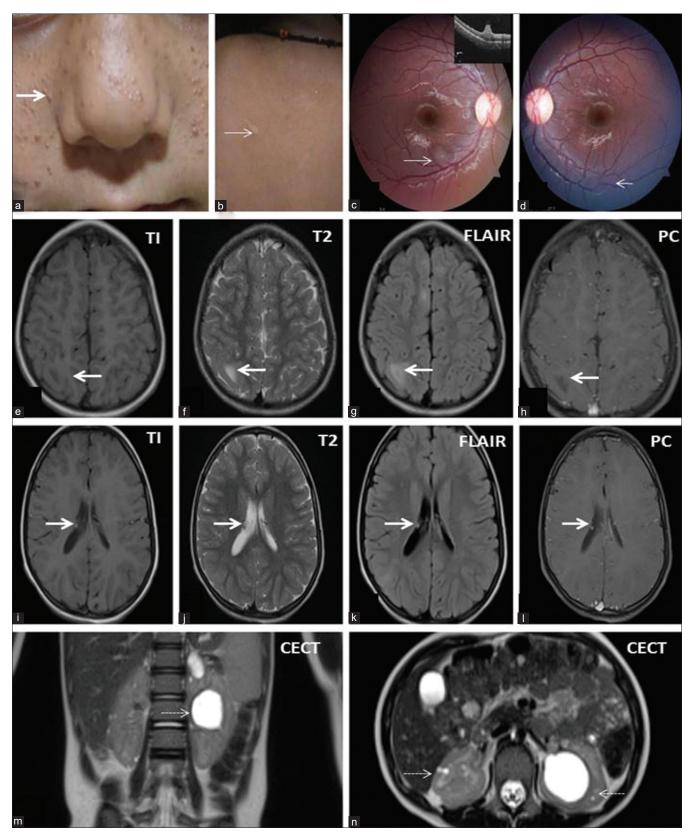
Clinical photograph (a and b) showing adenoma sebaceum (a) and ash-leaf macules (b). Fundus picture (c and d) of both eyes showing retinal astrocytic hamartomas (RAH). MRI brain revealed cortical tubers (e-h) and subependymal nodules (i-l). CECT showing dilated pelvicalyceal system (m) and multiple subcentimetric cysts in bilateral renal parenchyma (n)
